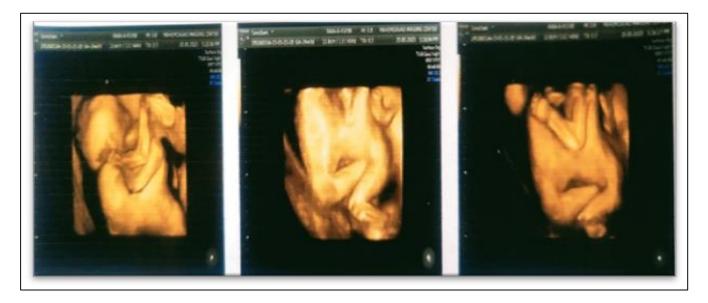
Ultrasonography of the fused twins at 22 weeks of gestation
